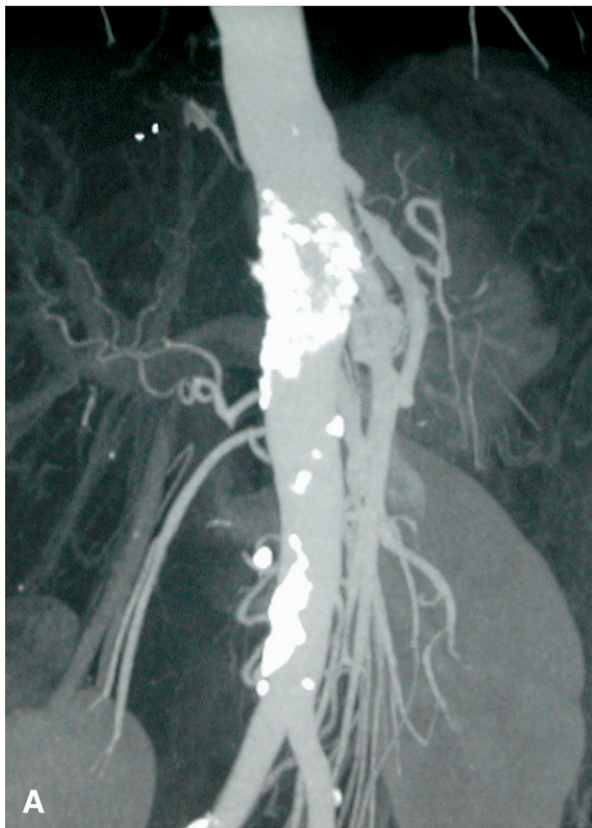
Preoperative computed tomographic scan view showing the celiac coral reef protruding into the visceral arteries (A) with occlusion of the main right renal artery (B). (C) Intraoperative view showing removal of the coral reef with laparoscopic grasping forceps. *Arrow*, Proximal supraceliac aortic clamp; *dotted arrow*, celiac trunk controlled with a bulldog clamp.
